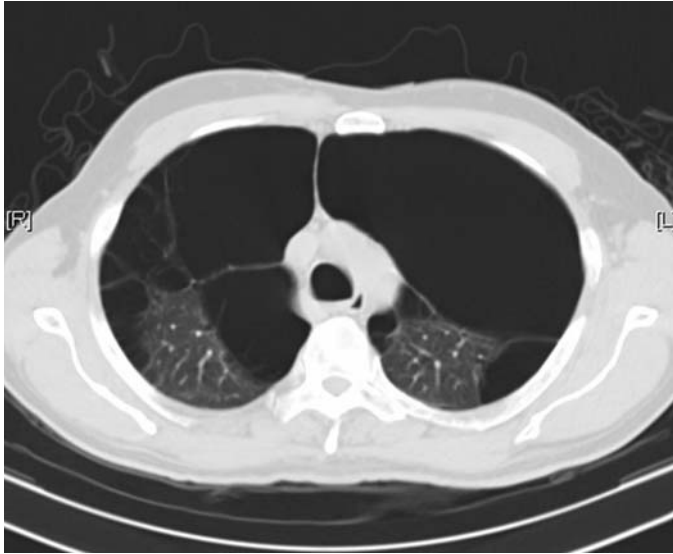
FIGURE e24-10 CT scan of bullous emphysema.
